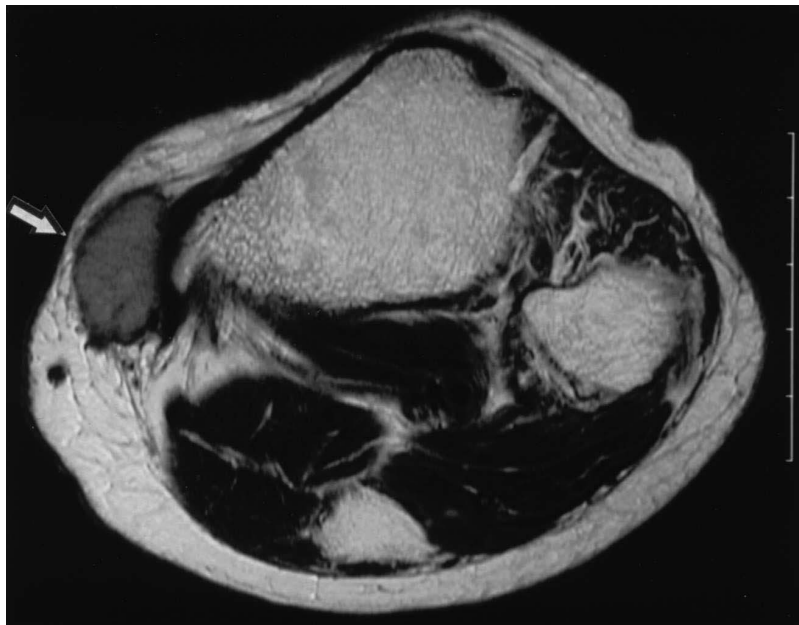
T2 weighted magnetic resonance imaging showing slightly high intensities of the tumor (arrow) and no involvement of the intramedullary portion of the tibia.
